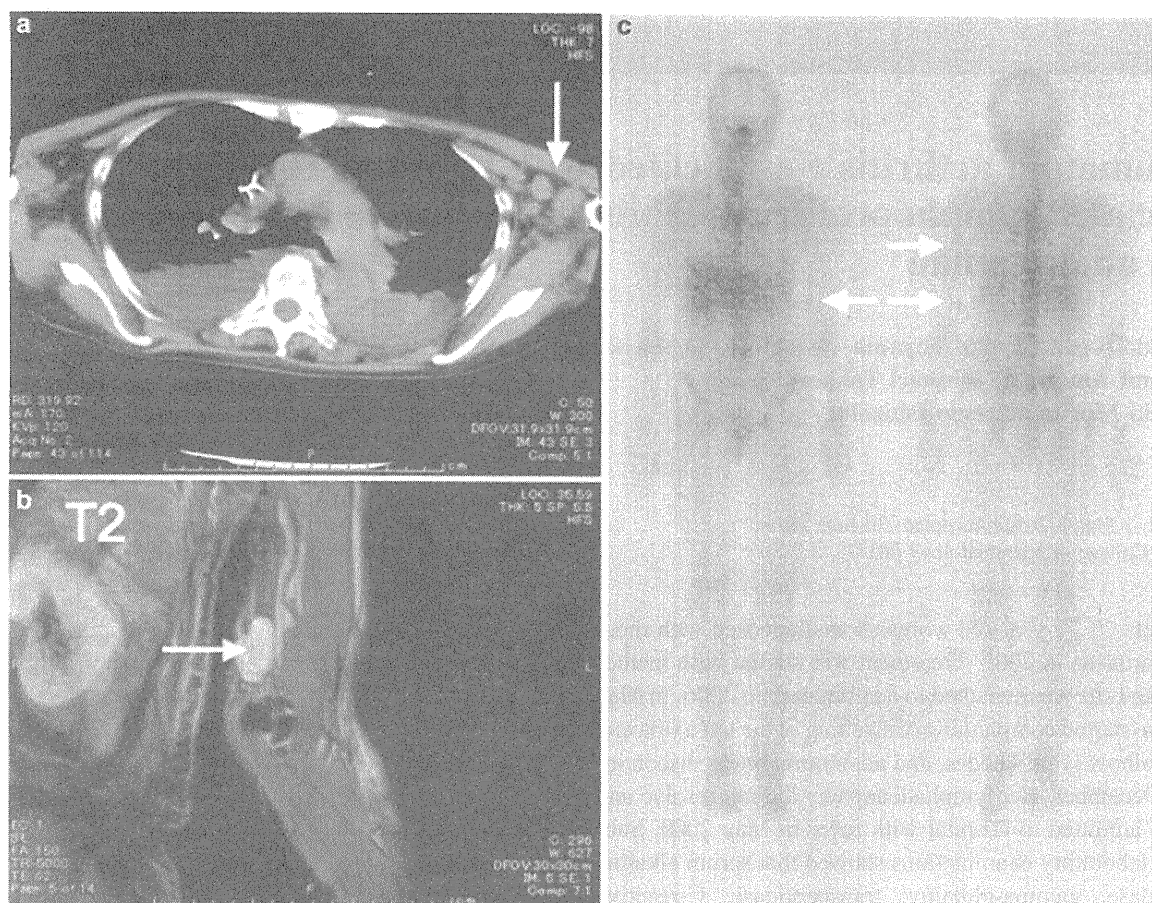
A chest computed tomography (CT) scan showing swollen left axilla lymph nodes (arrow; a). Magnetic resonance imaging (MRI) showing swollen left elbow lymph nodes (arrow; b). Gallium
